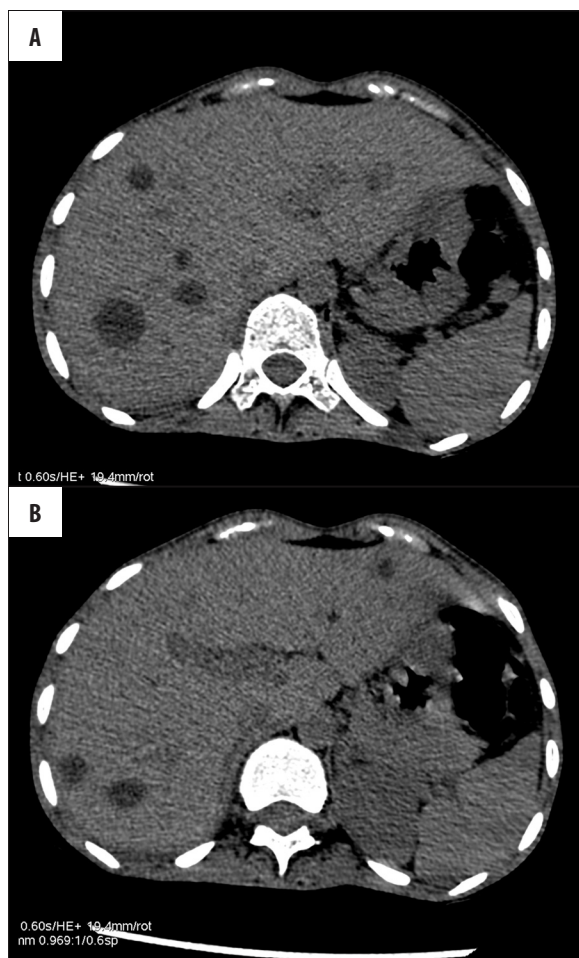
Plain CT of the abdomen showing presence of (A, B): multiple round hypodense areas in both lobes of the liver, the largest one was seen in the right lobe; (C) similar-density small lesions were also seen in the spleen.
